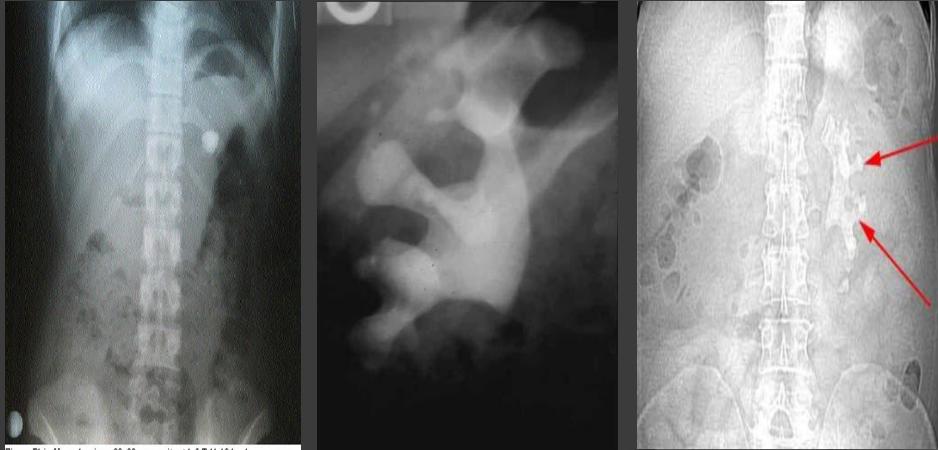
Plain X-ray showing a 23×23mm opacity at left T-11-12 level.
